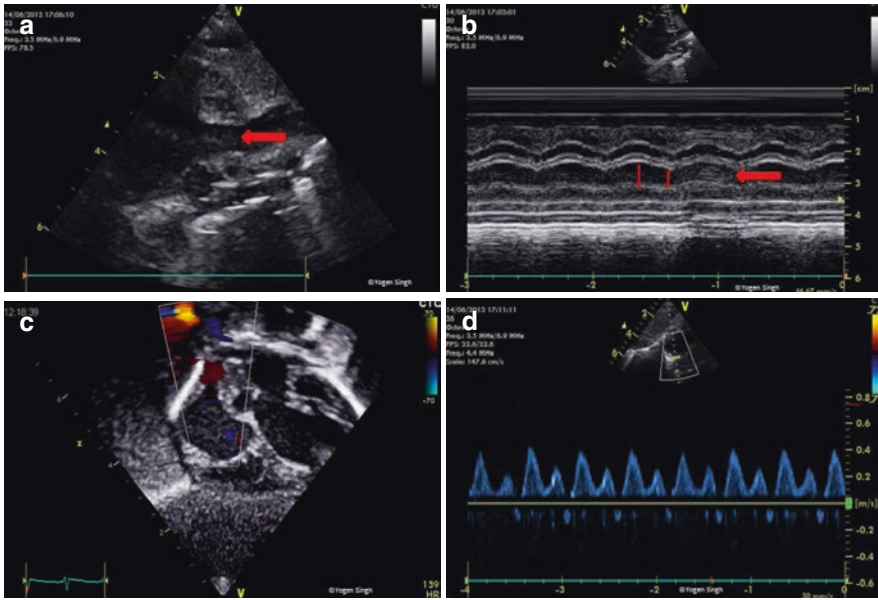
Measurement of superior vena cava (SVC) flow on echocardiography. (a) SVC in modified parasternal short axis view (PSAX) on 2D and (b) measurement of SVC diameter in M-mode. (c) Acquisition of color flow Doppler in sub-costal view and (d) SVC flow in mL/min
